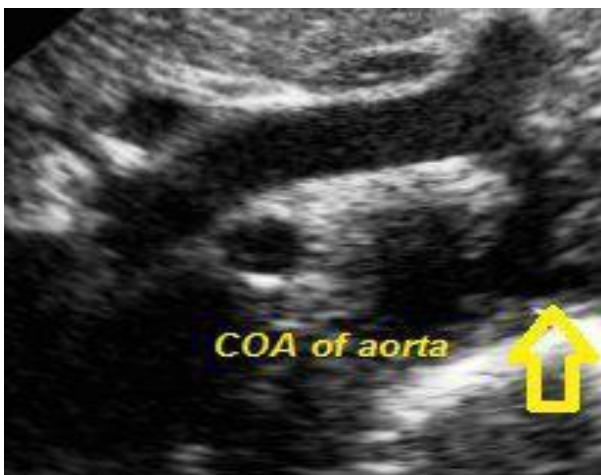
Suprasternal notch view in transthoracic echocardiography showed coarctation of the aorta (CoA).
